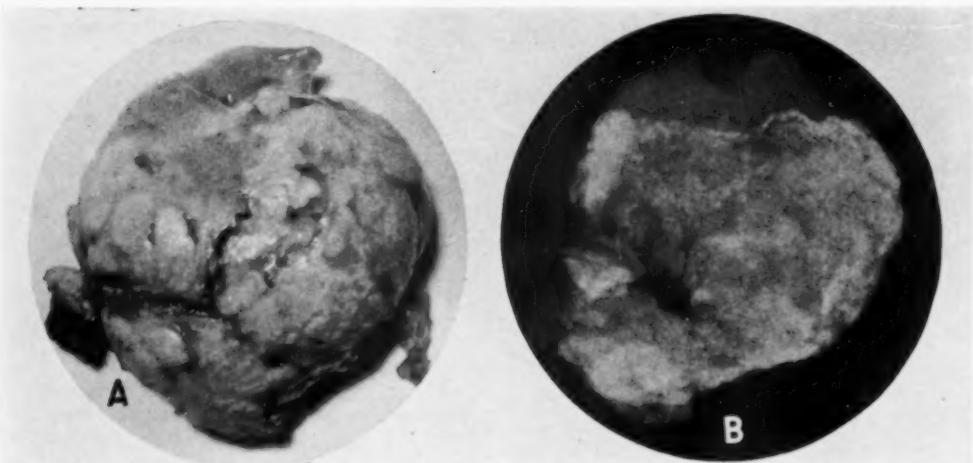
Photograph (A) and roentgenogram (B) of major fragment of polyp, demonstrating the peripheral calcification which had been visible *in vivo*.
